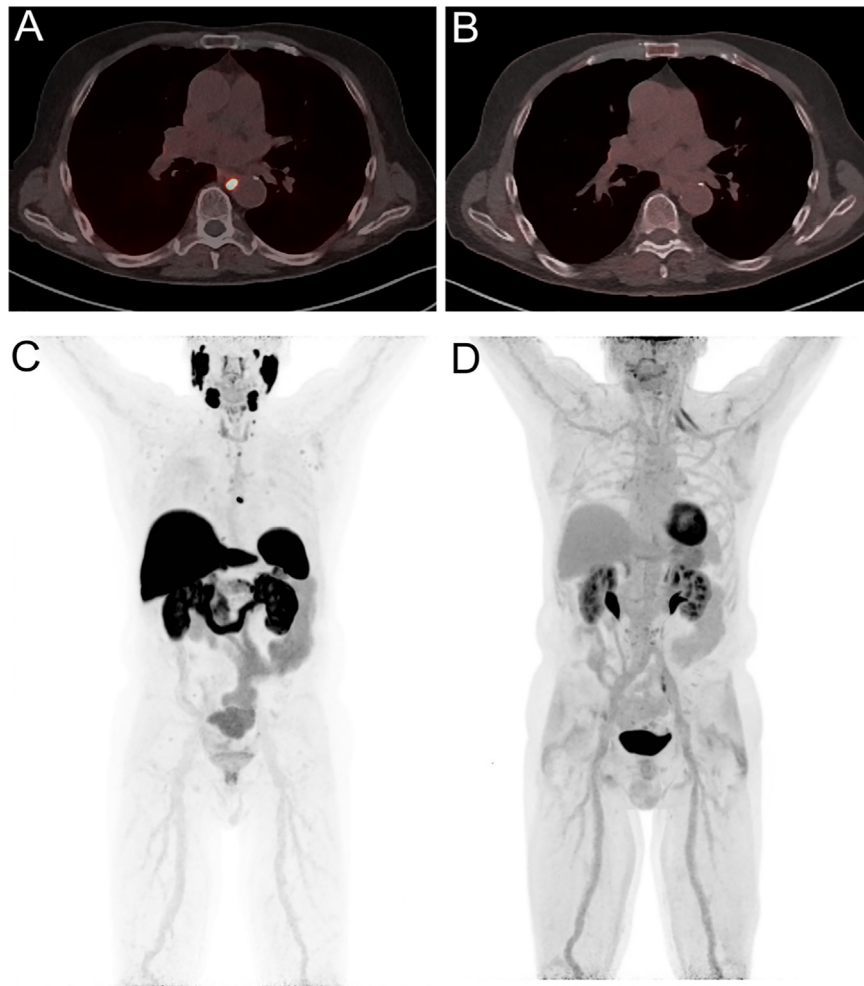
A case study demonstrates the importance of dual-tracer imaging in evaluating eligibility for ^{177}Lu -PSMA therapy. The patients underwent both examinations with an interval of 3 days. The top row shows a lymph node metastasis with strong PSMA-accumulation (A), which had no relevant FDG-accumulation (B). Panel (C and D) depict the representative MIPs of the two PET examinations. No FDG-PSMA mismatch was observed and the patient was referred to LuPSMA therapy. LAFOV-PET could facilitate the acquisition of both examinations by either doing them with no gap between or even simultaneously.
